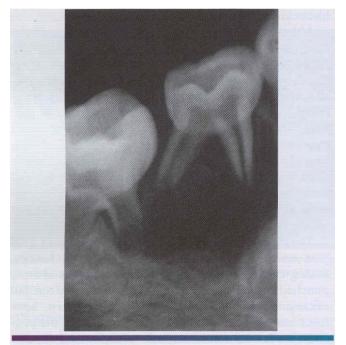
• langerhans cell histiocytosis. Periapical radiograph showing marked bone loss involving the mandibular teeth in a young girl. resulting in a "floating-in-air" appearance of the teeth.
